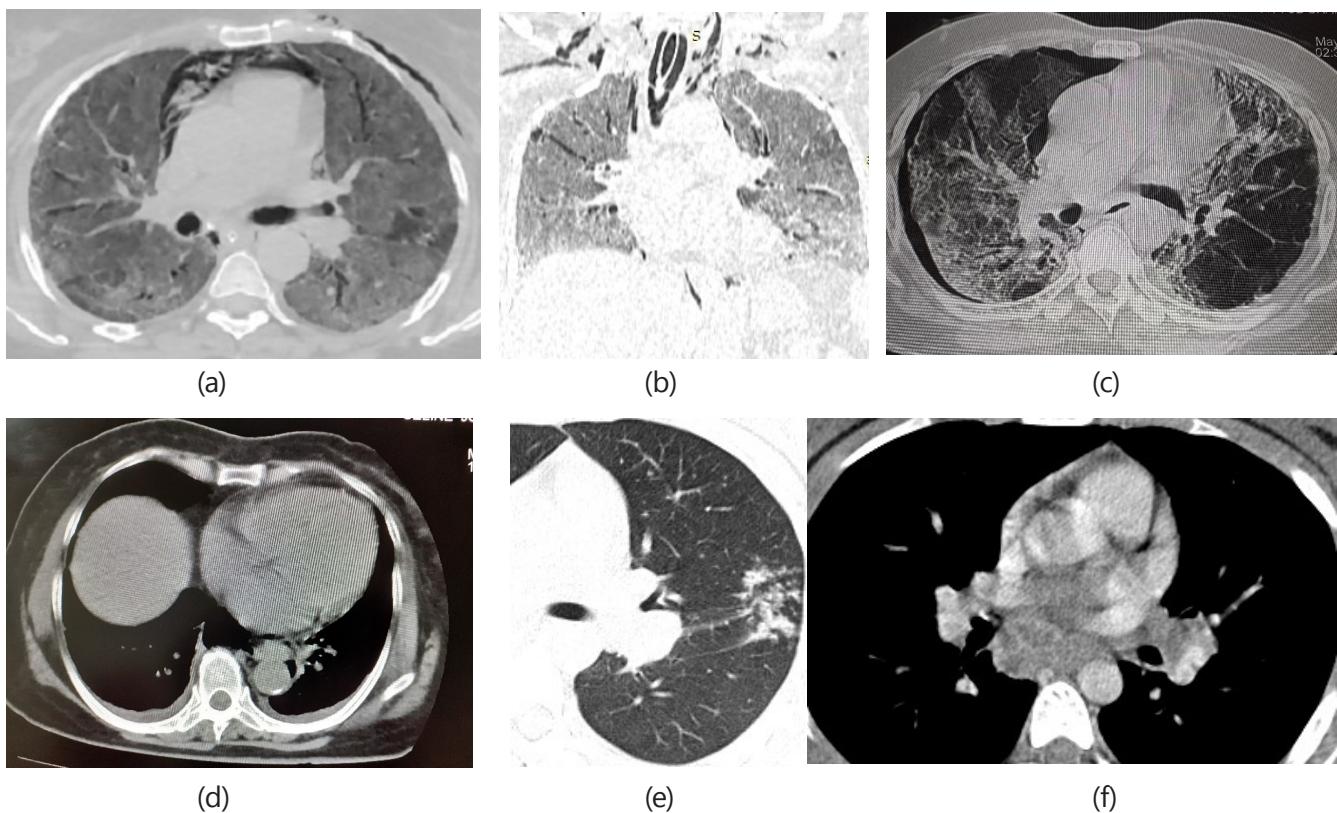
Uncommon HRCT findings of Covid-19 Pneumonia: Fig (a), (b), (c) Axial HRCT chest image shows pneumomediastinum, Subcutaneous emphysema and right sided pneumothorax in a patient with a high CT severity score(d)Axial HRCT image showing minimal bilateral basal pleural effusion and thickening. (e)Axial HRCT image showing small nodular air space opacities (f) mediastinal lymphadenopathy in a patient with Covid -19 pneumonia
